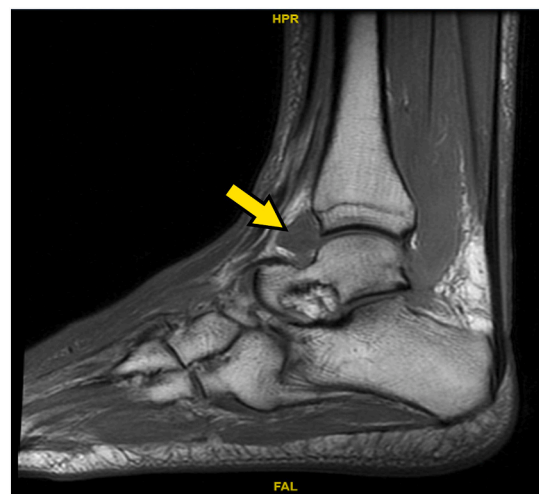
MRI of right ankle with abscess (arrow).
